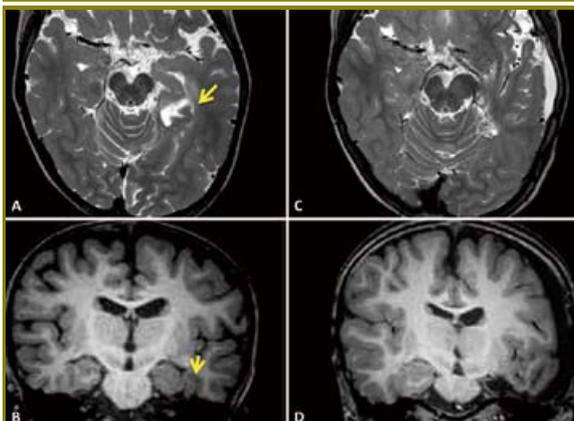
A 28-month-old child with infantile spasm. She became seizure-free (Engel class Ia) after 2 operations. A and B: Pre-operative T2-weighted axial MRI image, and T1-weighted coronal MRI image showing the mesio-temporal FCD (yellow arrow). C and D: Post-operative MRI images. Source: From personal collection.
